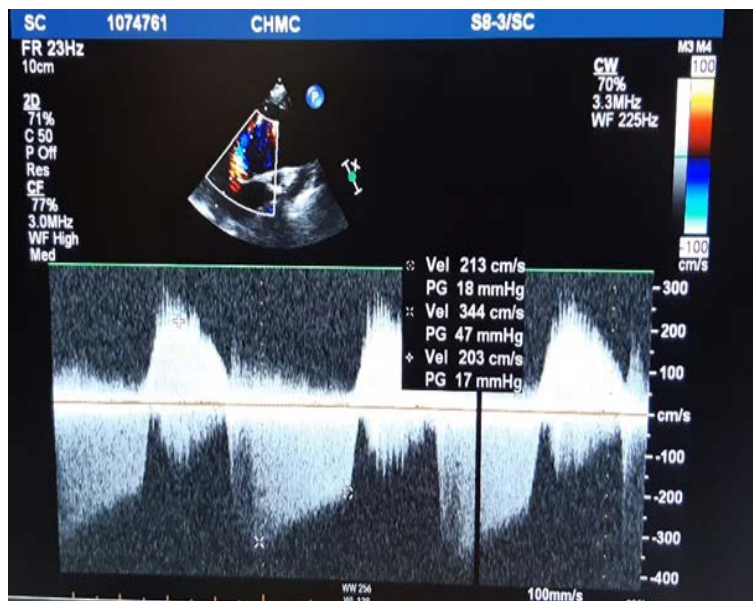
Acquisition of velocity and pressure data from echocardiogram.
